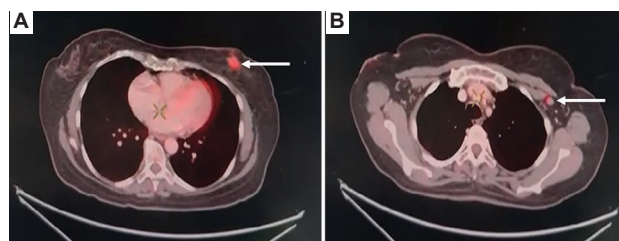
Whole-body 18F-fluorodeoxyglucose (FDG) positron emission tomography-computed tomography scan. (A) A $2.1 \times 1.3 \times 1.3$ cm metabolically active, spiculated soft tissue lesion is observed in the lower inner quadrant of the left breast (SUV_{max} 5.89). (B) Enlarged left axillary level I lymph nodes with increased FDG uptake (SUV_{max} 3.2).
